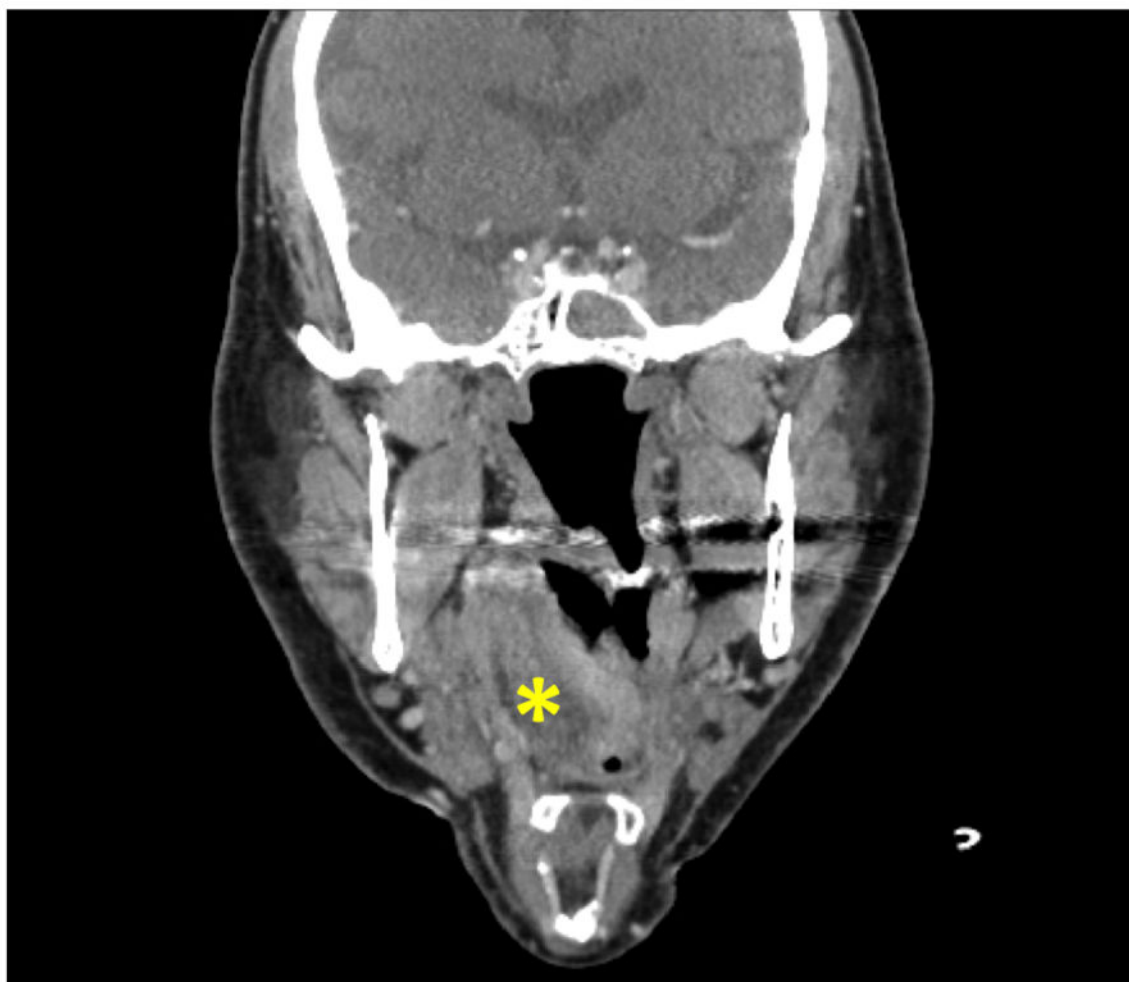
Non-contrast computed tomography (CT) scan of the neck in a patient with hypoglossal nerve palsy (HNP). Asymmetric heterogeneous soft tissue swelling in the right anterolateral oropharynx, marked with an asterix (*), extending from base of the tongue to vallecula, is seen on the coronal section.
